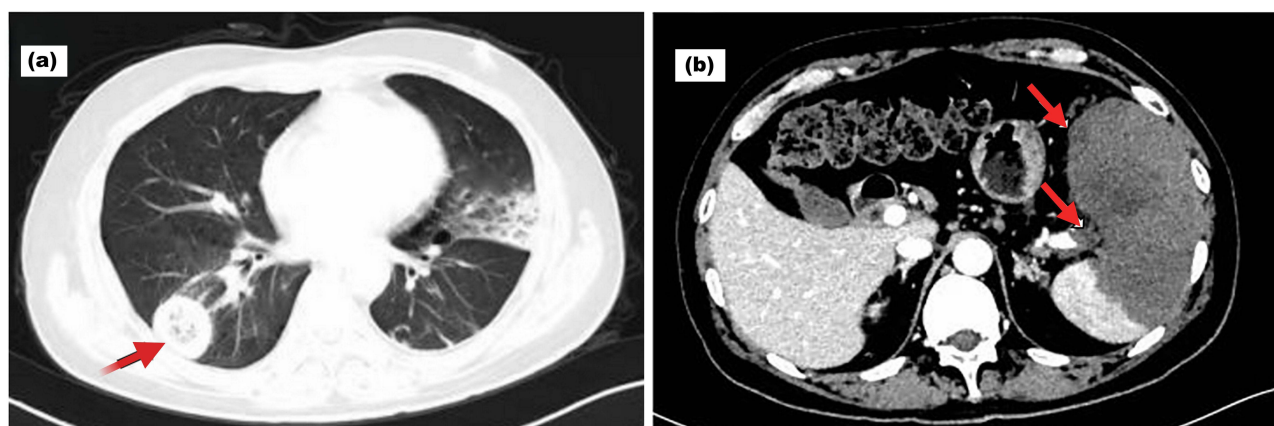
(a) Chest computed tomography (CT) scan demonstrating a nodule in the lower lobe of the right lung with a reversed halo sign (arrow), indicative of possible invasive fungal infection. (b) Contrast-enhanced abdominal CT revealing splenic artery embolism (lower arrow) and splenic infarction (upper arrow).
